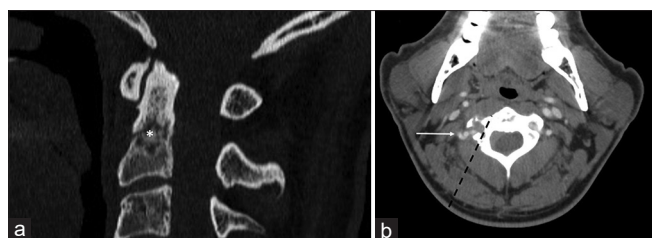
(a) A sagittal view of a computed tomography (CT) scan showing a lytic lesion within the body of the axis (asterisk). (b) An axial view of a contrast-enhanced CT scan, highlighting the course of the vertebral artery (arrow), which appears to be compressed and dislocated by the tumor which invades the foramen of the vertebral artery
